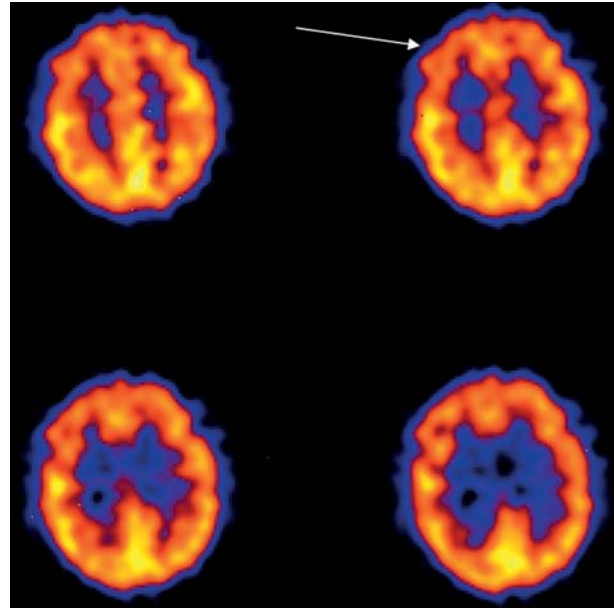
Transaxial SPECT images of ^{99m}Tc bismuth citrate in normal aging with decreased bilateral frontal lobe perfusion (arrow).
